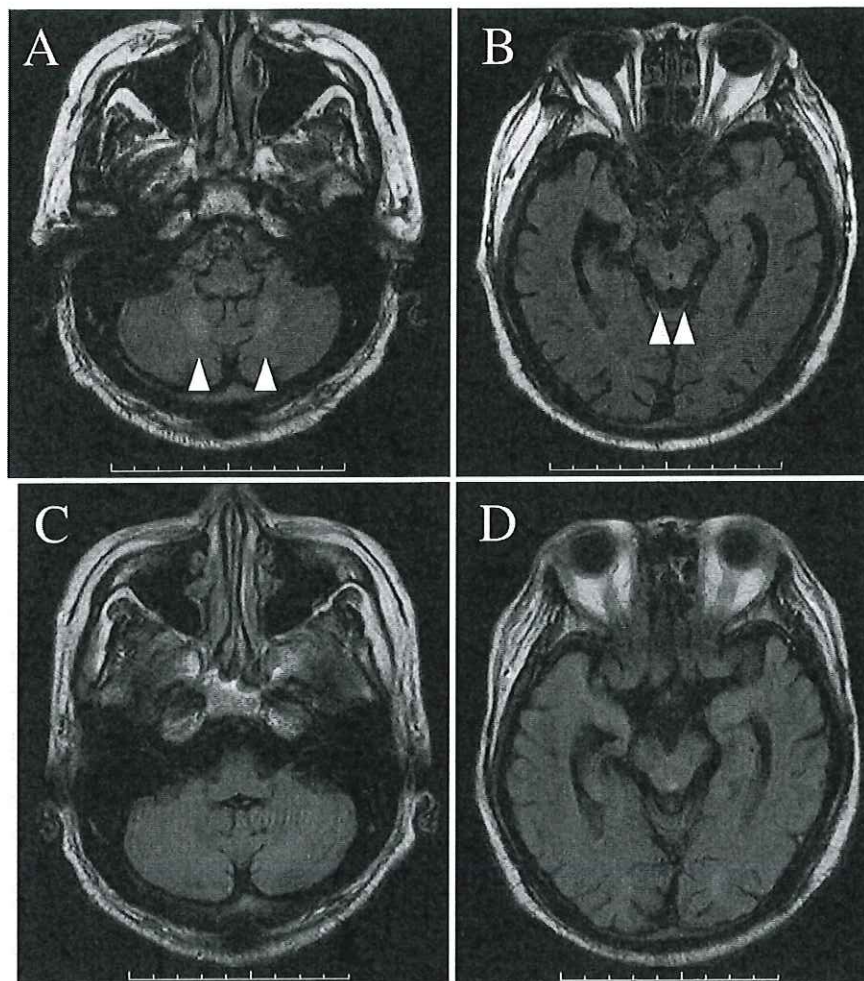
Brain magnetic resonance imaging revealed symmetrical hyperintensities in the dentate nuclei, tectal plate, and periaqueductal area on fluid-attenuated inversion recovery images (A, B; indicated with white arrowheads). There were no abnormal findings in the mammillary bodies or thalami. Follow-up brain magnetic resonance imaging was performed four months after treatment and revealed that the abnormal signals previously seen had disappeared (C, D). Note that the hyperintensity in the midbrain aqueduct (D) was due to an artifact associated with the flow of cerebrospinal fluid.
